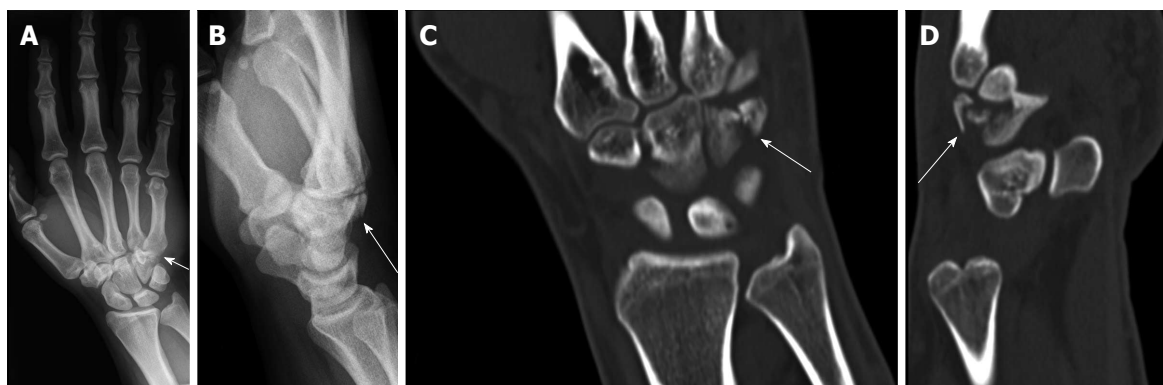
Conventional radiography (A and B) and multidetector computed tomography (C and D) revealed an acute hamate fracture as a secondary finding.
